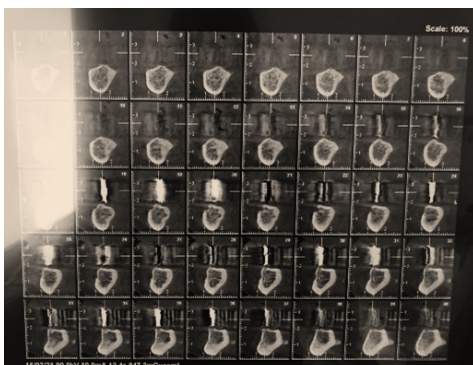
Patient's Cone Beam
